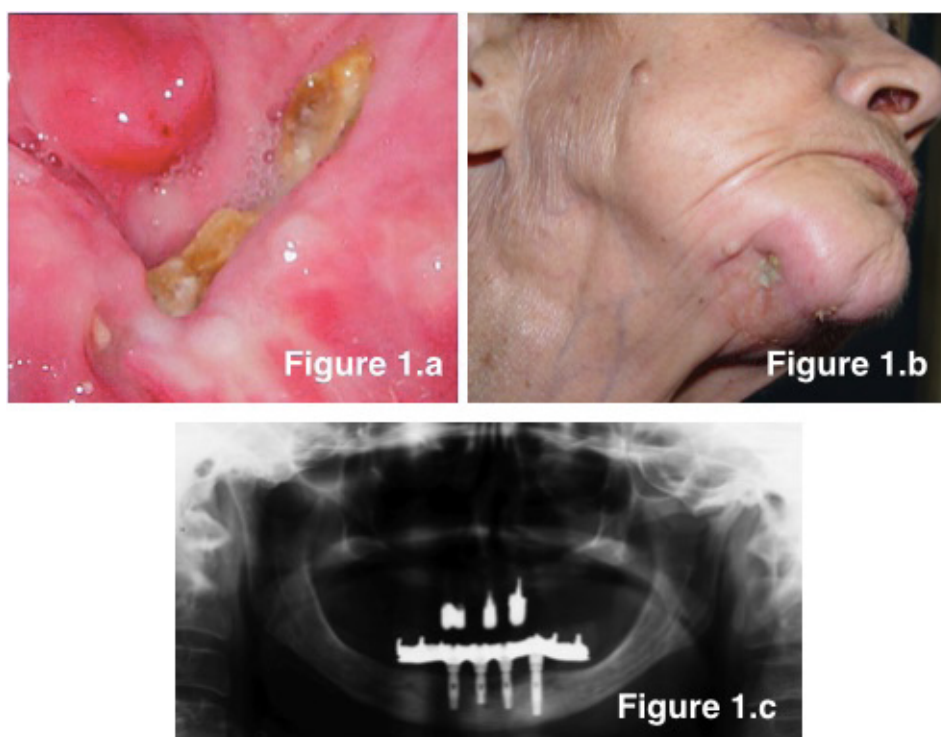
a) Exposed osseous sequestration; b) Initial view: extraoral fistulous tract; c) Initial panoramic radiograph showing dental implants
